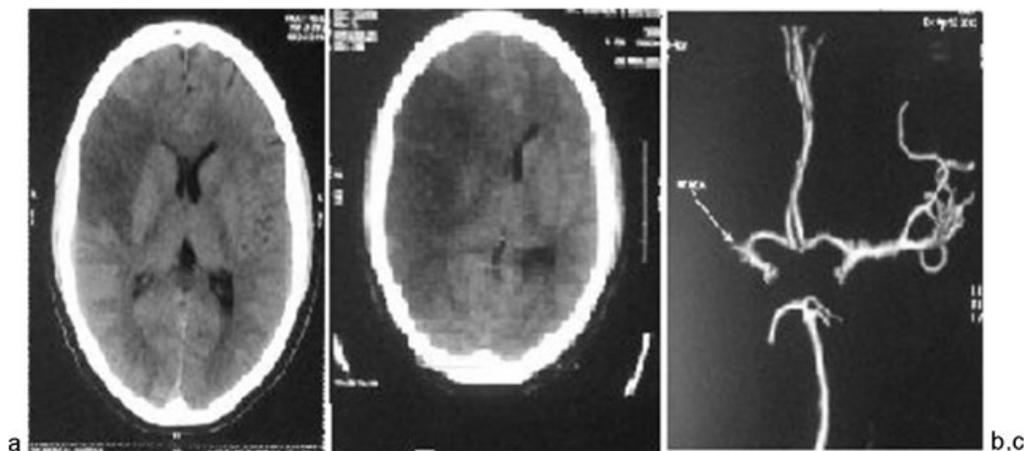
Case 1: (a) Initial computed tomogram showing infarction in the middle cerebral territory. (b) Increased size of infarction with edema. (c) Computed tomographic angiogram showing occlusion of middle cerebral artery in M1 segment.
